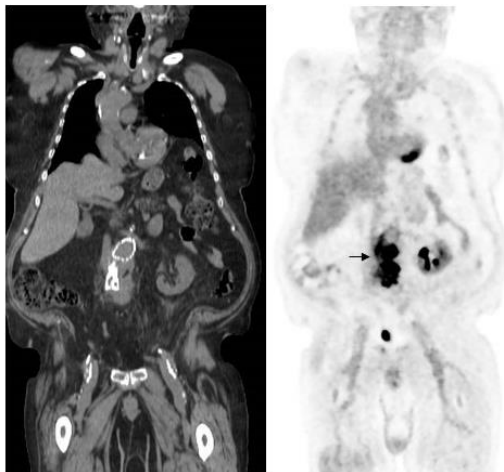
Infected abdominal aortic endovascular stent. Note the irregular, intense  $^{18}\text{F}$ -FDG uptake in the stent (arrow).
